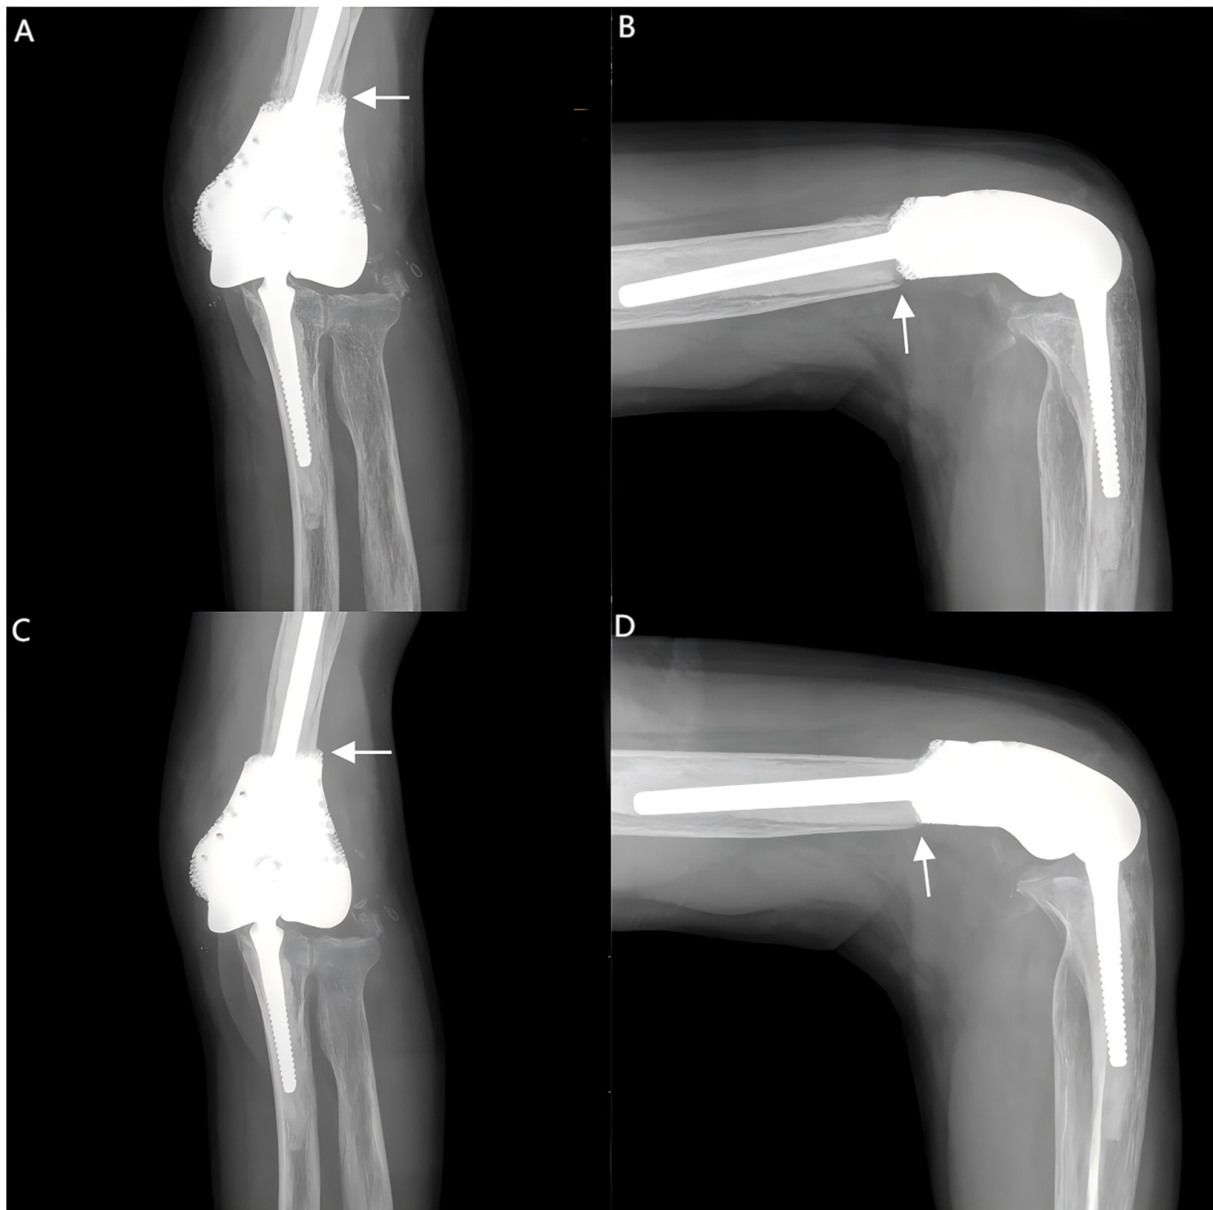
(A) Day 1 anteroposterior X-ray; (B) day 1 lateral X-ray; (C) 6-month anteroposterior X-ray; (D) 6-month lateral X-ray. The arrows indicate the integration status of the prosthesis with the bone interface.
